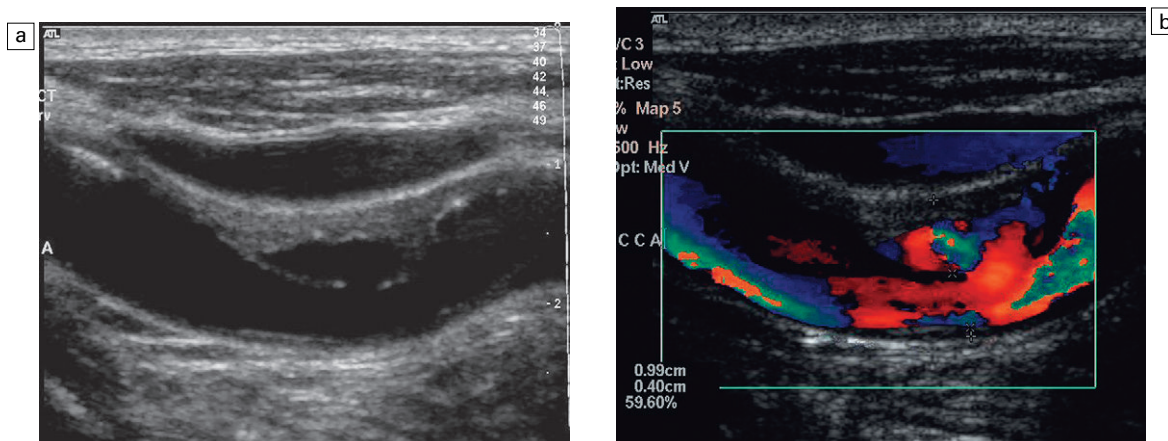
An ulcerated plaque. A thin rim is seen on the B-scan image (a) but colour Doppler (b) shows flow within the plaque.
